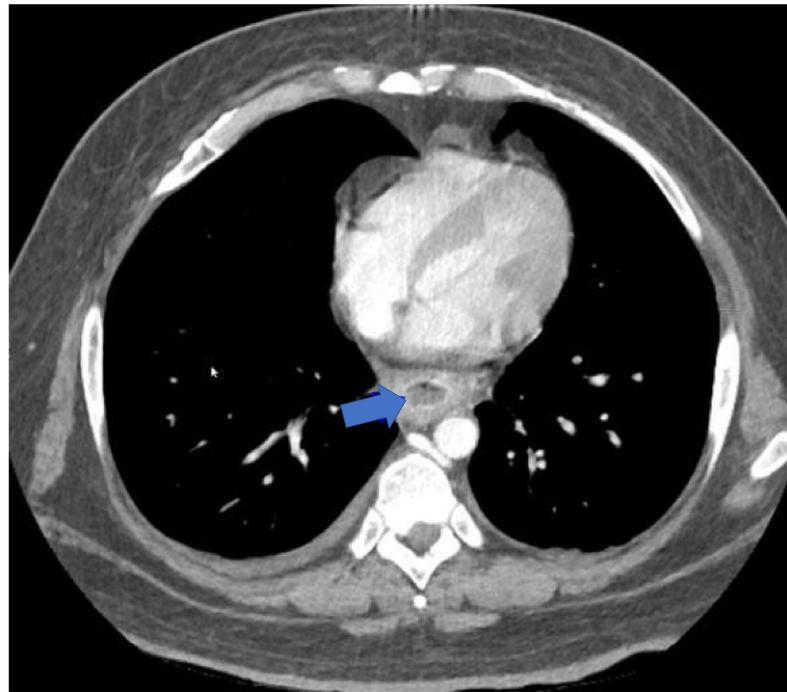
Axial IV contrast-enhanced CT of the thorax in the mid-lower esophagus and abdomen. Figure 1. shows circumferential wall thickening with external wall enhancement with lack of mucosal enhancement (blue arrow). This is a non-specific finding.
